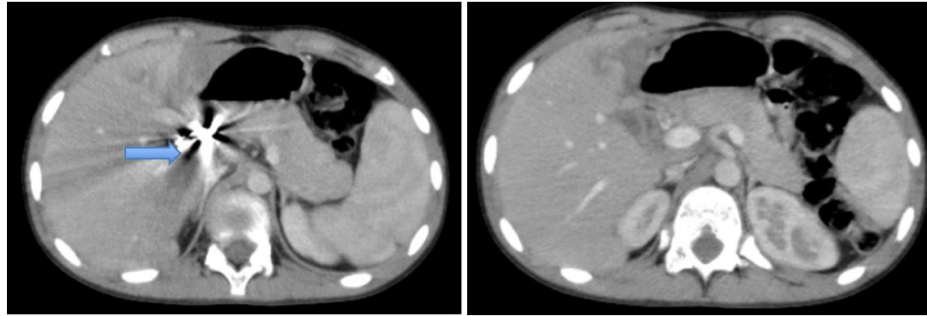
Follow-up CT. (A) Spontaneously hyperdense material related to embolization coils within the psuedoaneurism (blue arrow). (B) regression of hemoperitoneum
